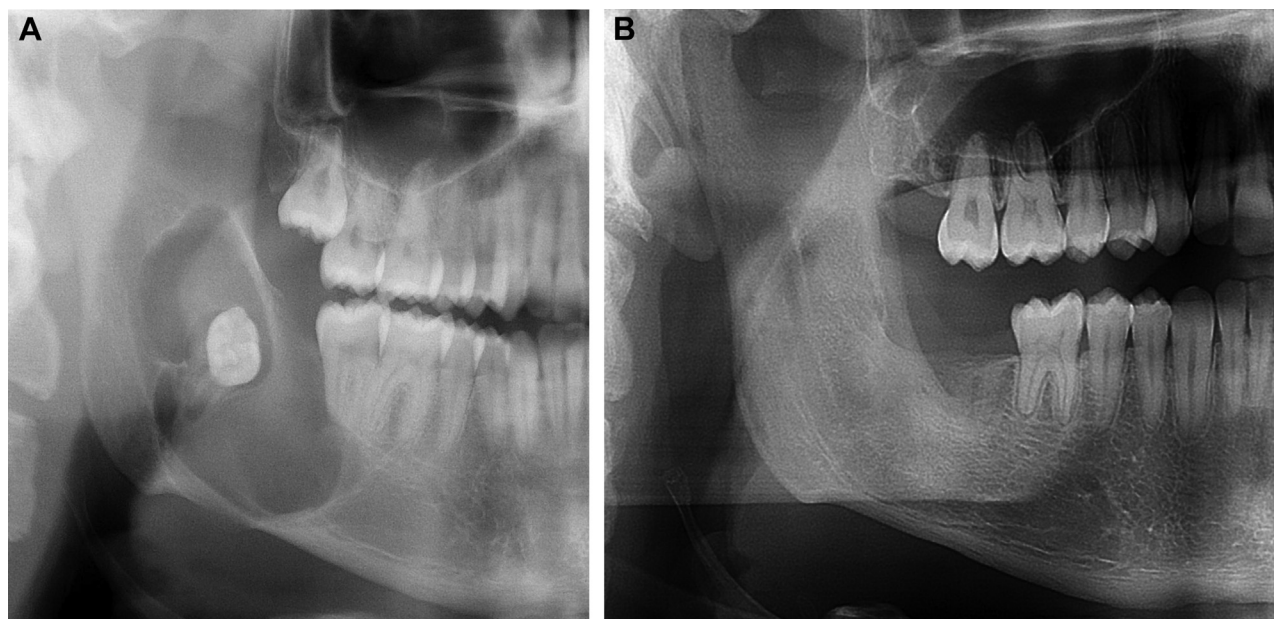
Representative example of odontogenic keratocyst treated with refined topical 5-fluorouracil technique. A, Preoperative Panorex radiograph showing a biopsy-confirmed odontogenic keratocyst involving the right mandibular body, and ramus. B, Six-month postoperative Panorex radiograph showing a well-healed, cyst-free right mandible treated with enucleation, peripheral ostectomy, and refined topical 5-fluorouracil technique.
